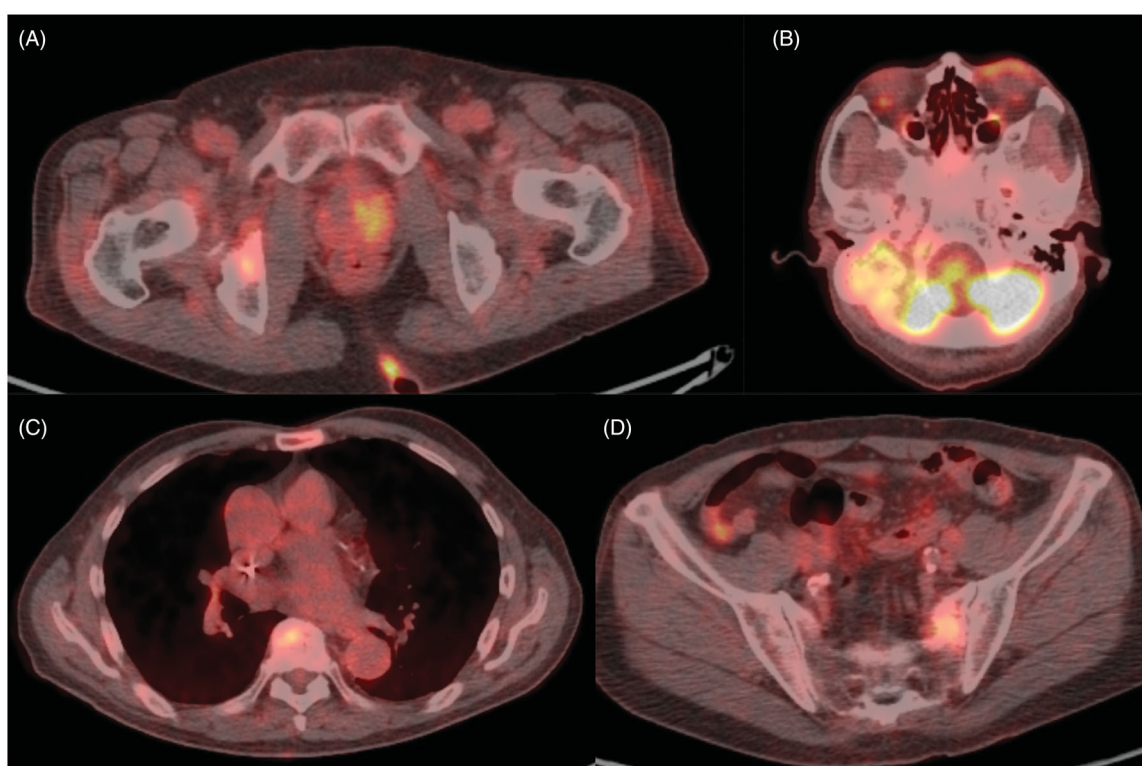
PET-CT imaging at the time of diagnosis. FDG-PET/CT showed accumulations on the left side of prostate (A), right temporal bone (B), vertebral body (C), and iliac bone (D). Bone sclerosis images consistent with the same site were observed.
